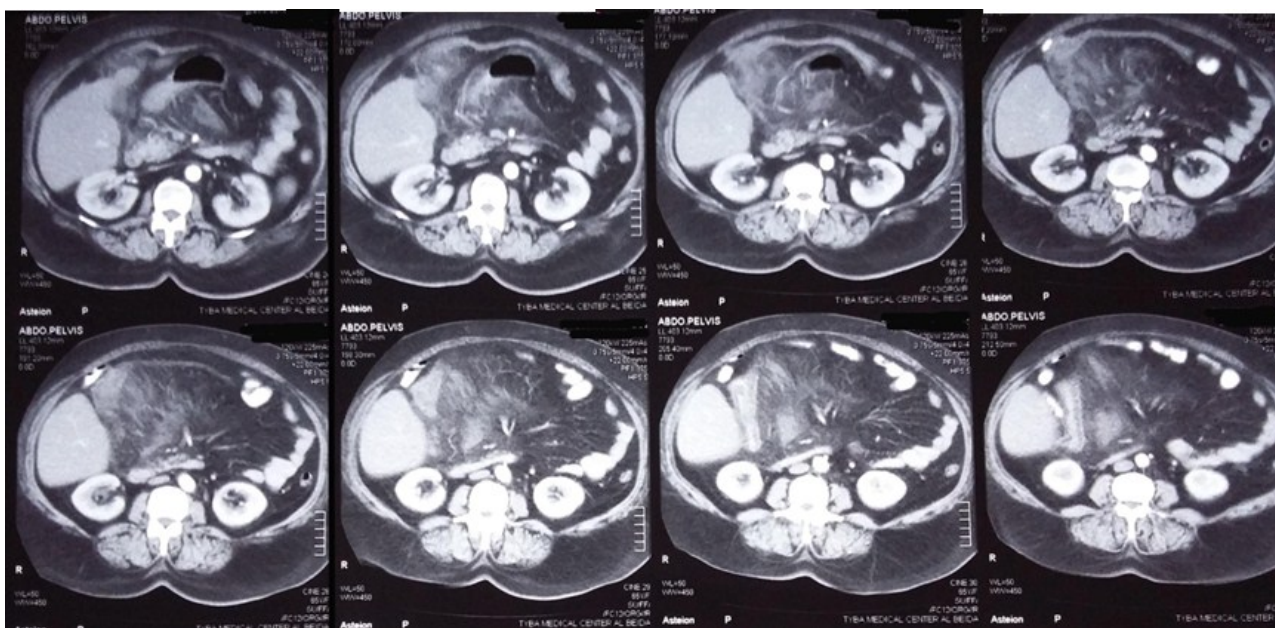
Abdominal and pelvic CT scan with contrast showing sandstorm appearance of mesenteric panniculitis (cross sectional view).
